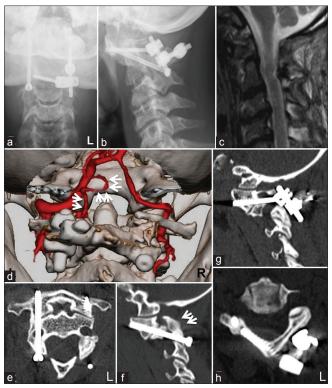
Postoperative radiographical examinations. (a and b) Anteroposterior and lateral view of cervical radiographs showing on-target atlantoaxial screw placements. (c) Sagittal T2-weighted MRI of the cervical spine showing decompression of the spinal cord at the CI level. (d) Posterior view of reconstructed 3D-CTA image at the craniovertebral junction showing a patent left PICA (arrows). (e-h) CT images at the I2-month follow-up showing the trajectory of each screw and bony fusion between CI and C2 (arrows)
